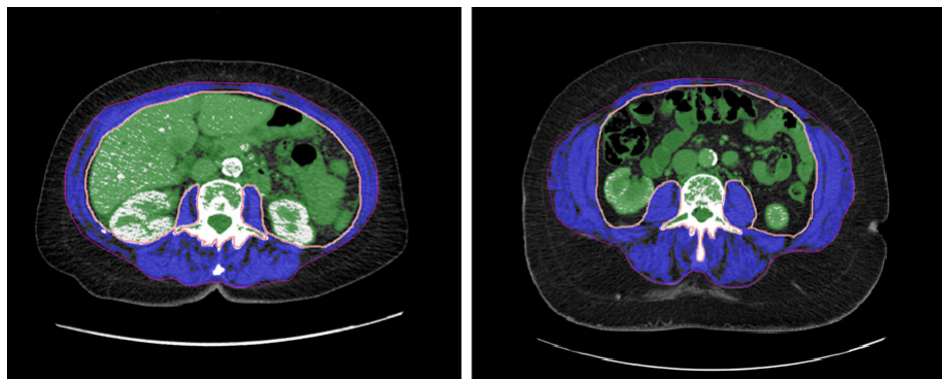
Cross-sectional abdominal CT image at the level of the vertebral transverse processes of L3 with segmentation of skeletal muscles (blue), viscera in green.
